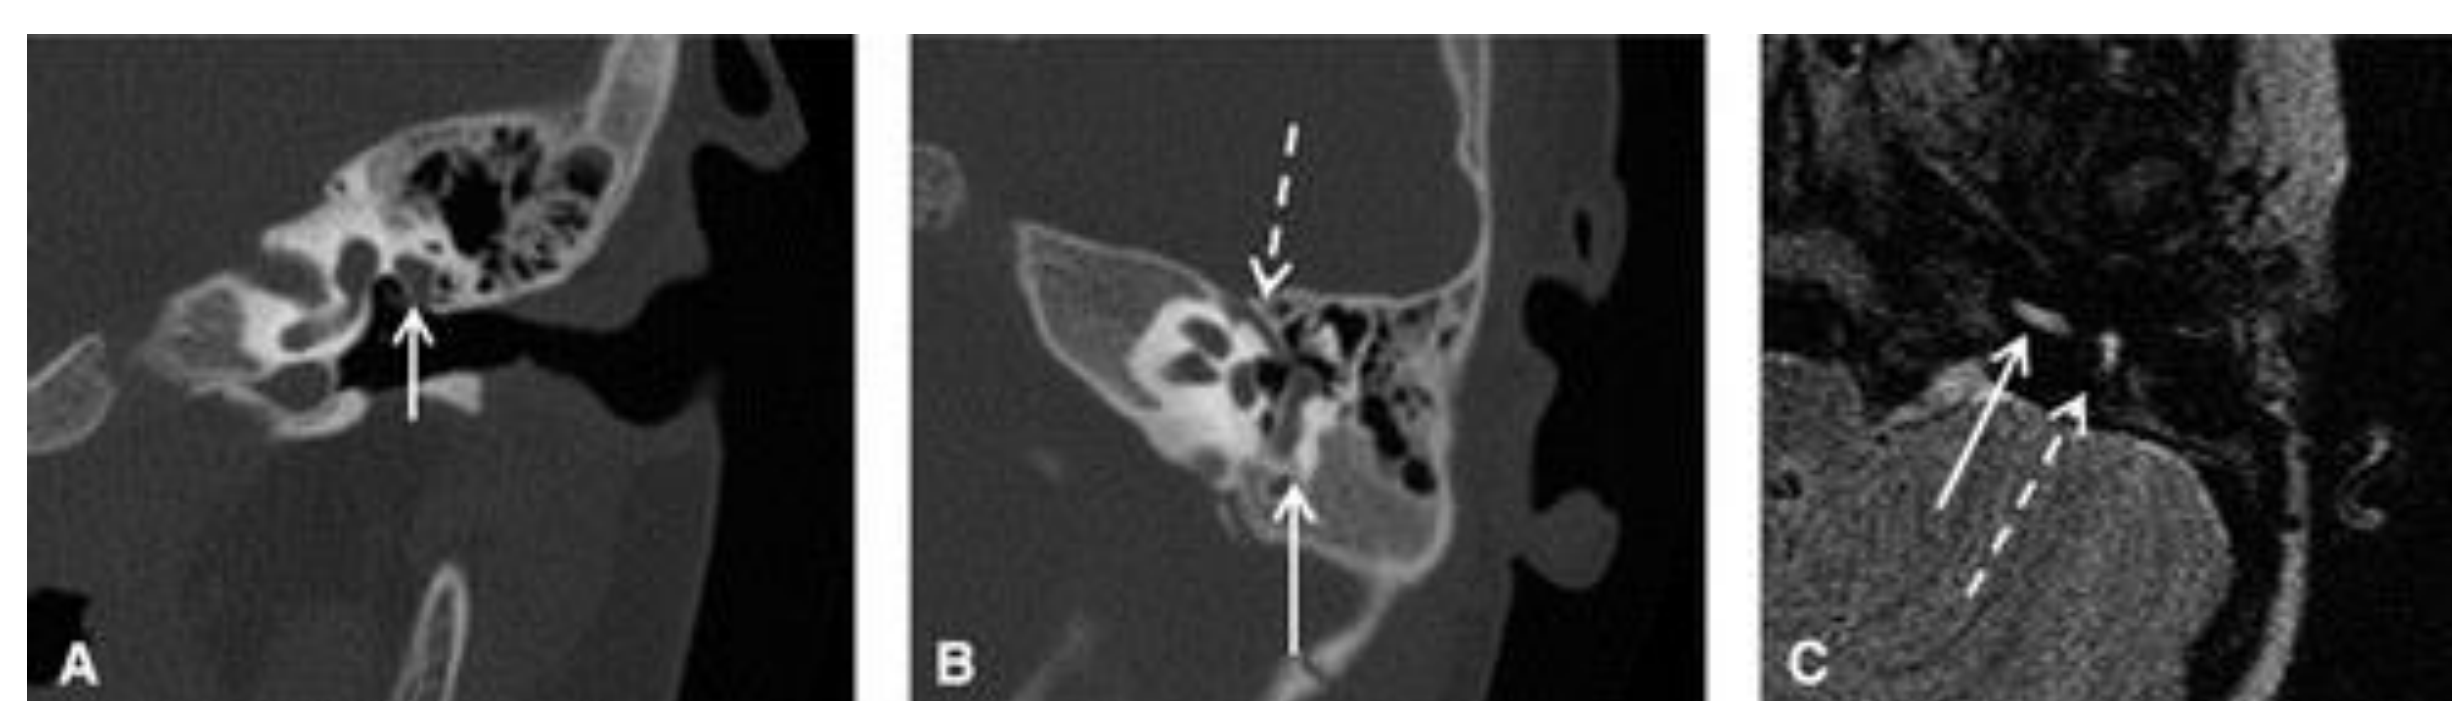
(A) Coronal noncontrast CT image of patient 1 at the level of the middle ear. The enlarged fallopian canal (arrow) can be seen in patient 1 (1.25-mm slice thickness). (B) Axial CT image at the level of the vestibule. The normal diameter of the proximal facial nerve (dashed arrow) can be contrasted with the enlarged fallopian canal (solid arrow) at the second genu. (C) Axial T2-fast spin echo MRI at the level of the basal turn of the cochlea (solid arrow). The facial nerve shows hyperintensity in the proximal mastoid portion (dashed arrow).
